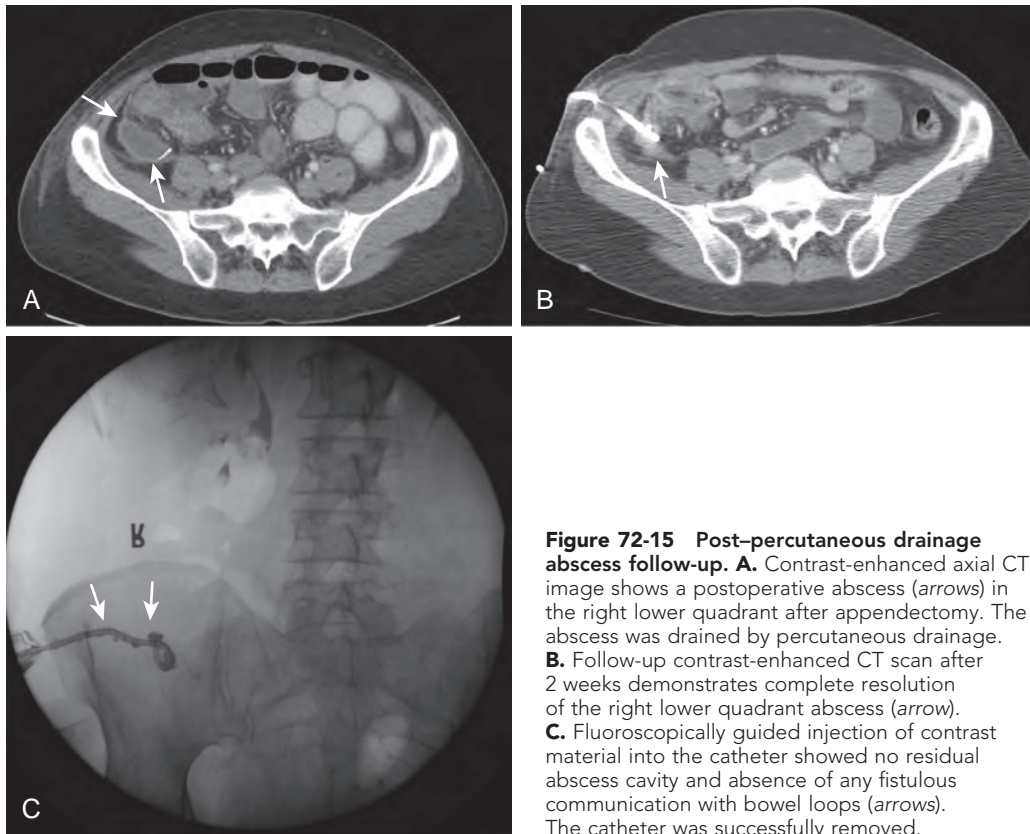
Post-percutaneous drainage abscess follow-up. A. Contrast-enhanced axial CT image shows a postoperative abscess (arrows) in the right lower quadrant after appendectomy. The abscess was drained by percutaneous drainage. B. Follow-up contrast-enhanced CT scan after 2 weeks demonstrates complete resolution of the right lower quadrant abscess (arrow). C. Fluoroscopically guided injection of contrast material into the catheter showed no residual abscess cavity and absence of any fistulous communication with bowel loops (arrows). The catheter was successfully removed.
